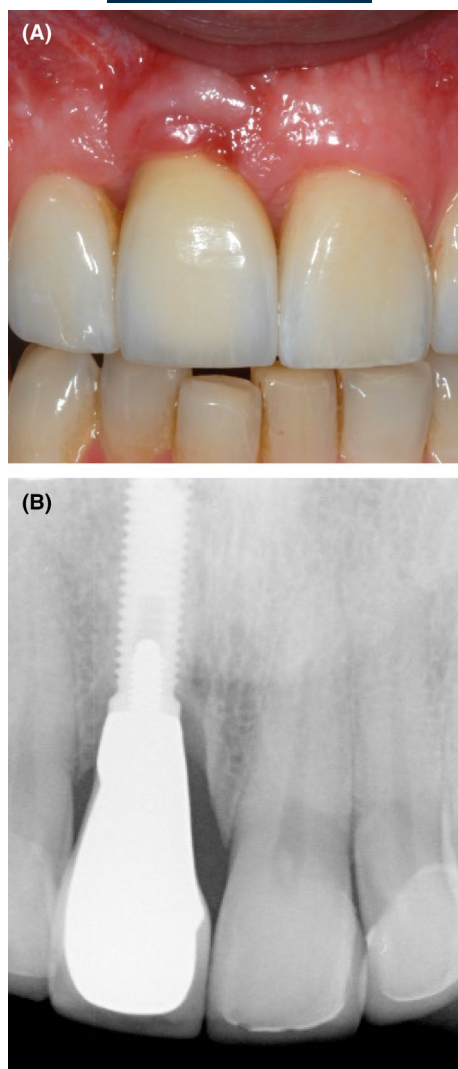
(A) This implant replacing the maxillary right central incisor has been placed in an apical malposition, that is, it has been too deeply placed. There is a persistent inflammation of the mucosa which could not be eradicated despite the patient's efforts at plaque control and regular supportive maintenance therapy. (B) The corresponding periapical radiograph shows the apical position of the implant shoulder. The implant has a machined surface with an external hex abutment connection.
